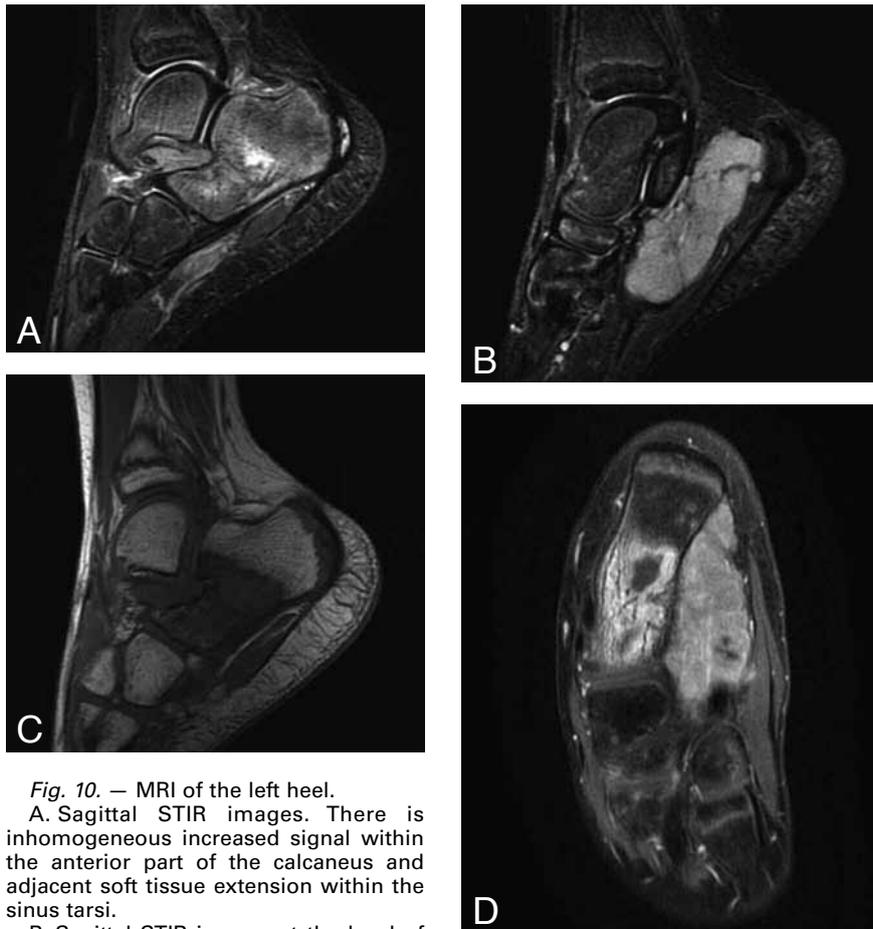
MRI of the left heel.
